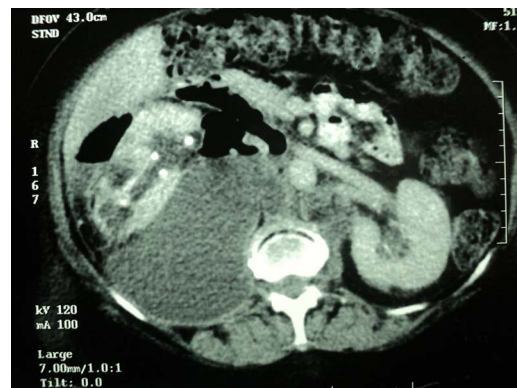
Axial CT section suggestive of the presence of the large collection present posterior-medial and lateral to the non-hydronephrotic right kidney.
